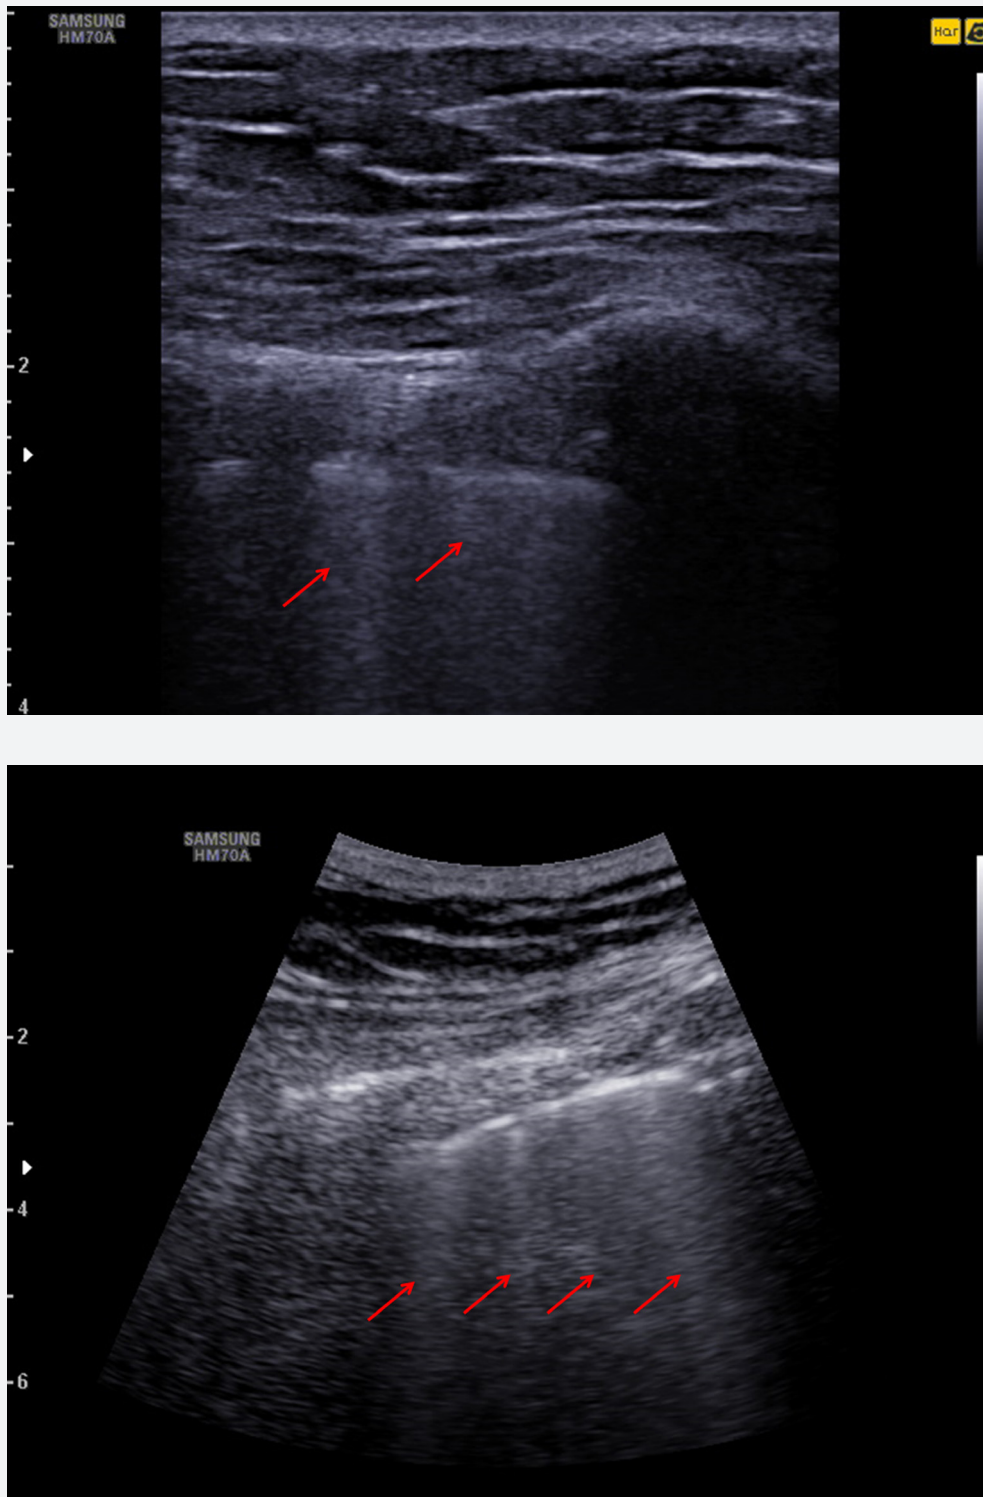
Lung ultrasound using the Samsung HM70A.
